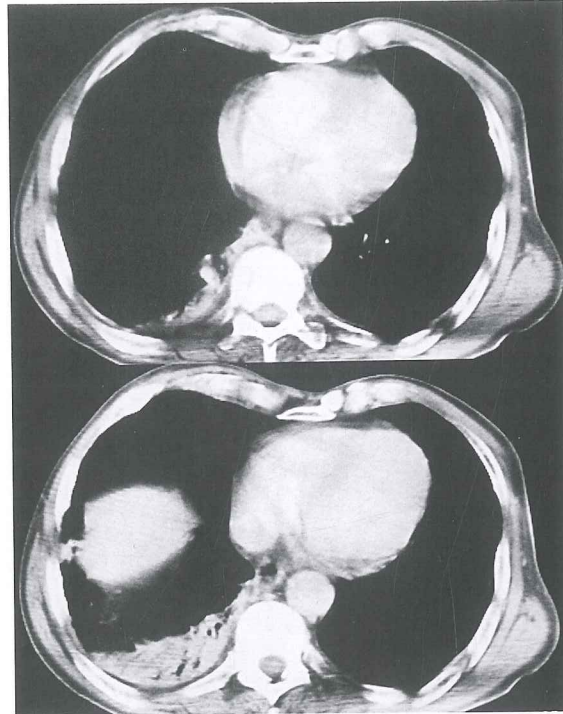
Thorax CT of the patient showing infiltration on posterior segment of right lower lobe.
